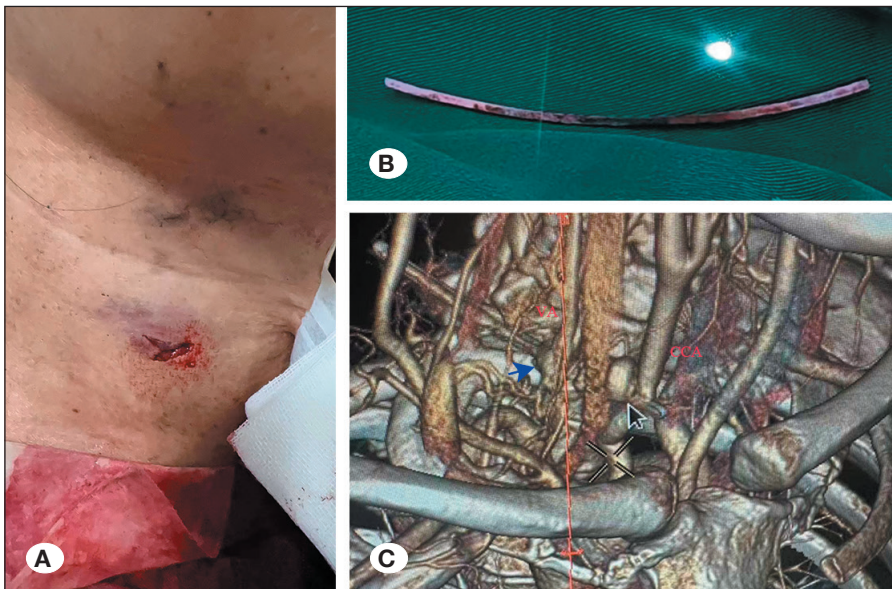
Preoperative images of case 1. A) The location of penetrating injury in the neck. B) Metal rod penetrating the neck. C) Preoperative CTA showing injured segments of the right CCA and VA. The blue arrow indicates the injured segment of the right VA and the black arrow indicates the injured segment of the right CCA. Abbreviations: CCA: common carotid artery; CTA: computed tomography angiography; VA: vertebral artery.
